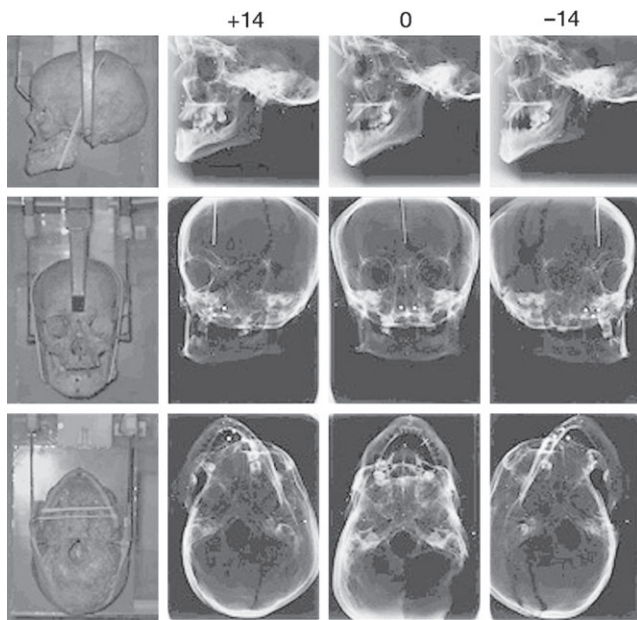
Positioning of the dry skull for lateral, postero-anterior (PA) and submentovertex (SMV) cephalometric radiography at a rotational angle of +14, 0 and -14 degrees. '+' indicates a rotation towards the focal spot, and '-' a rotation towards the film for lateral cephalograms and towards the right and left, respectively, for PA and SMV cephalograms.
